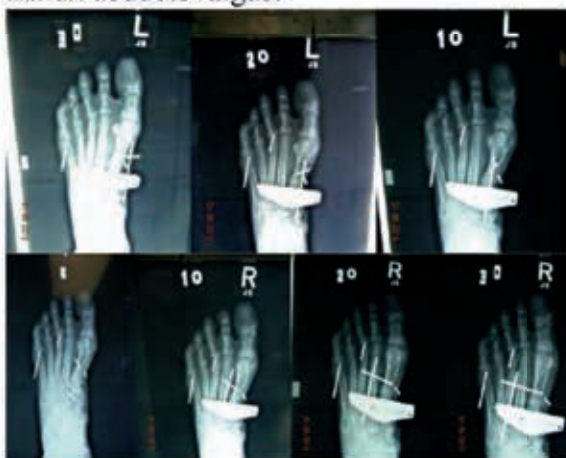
Radiographs showing effects of 1st metatarsal rotation starting at the top left image with 30° valgus with 10 degrees of increased varus with each successive film, ending with 30° varus at the bottom right showing correction of tibial sesamoid position with rotation of the metatarsal alone.⁶
